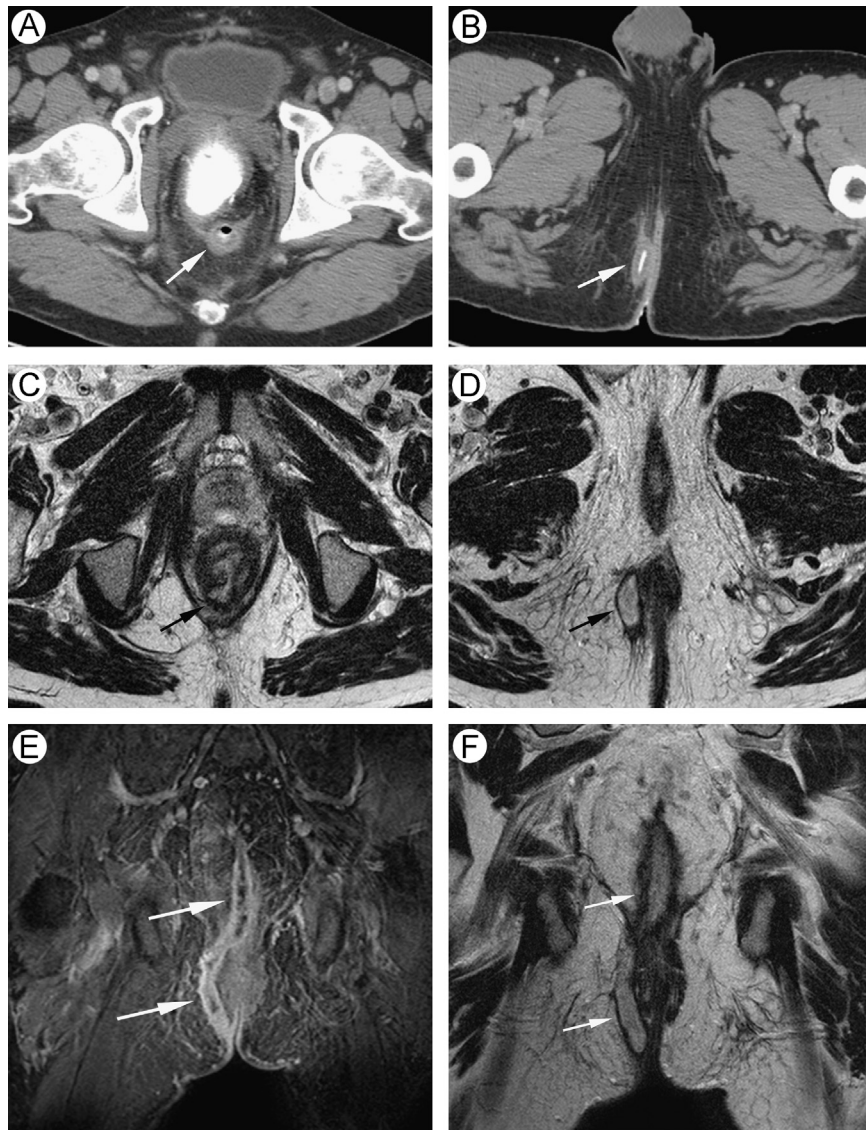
Axial CT images (A and B) in a patient with Crohn's disease after an IPAA shows a fluid collection in the pelvis posterior to the ileoanal anastomosis (A, white arrow) and a right perianal fistula containing enteric contrast (B, white arrow) that extends to the skin surface (not shown). Axial T2-weighted MR images (C and D) confirm the fluid collection as well as a patent perianal fistula at the 6 o'clock position (black arrows). Coronal T1 postgadolinium (E) and coronal T2-weighted (F) images demonstrate an intersphincteric fistula with supralelevator extension. This case exemplifies the close relationship between fistulae and Crohn's disease.
